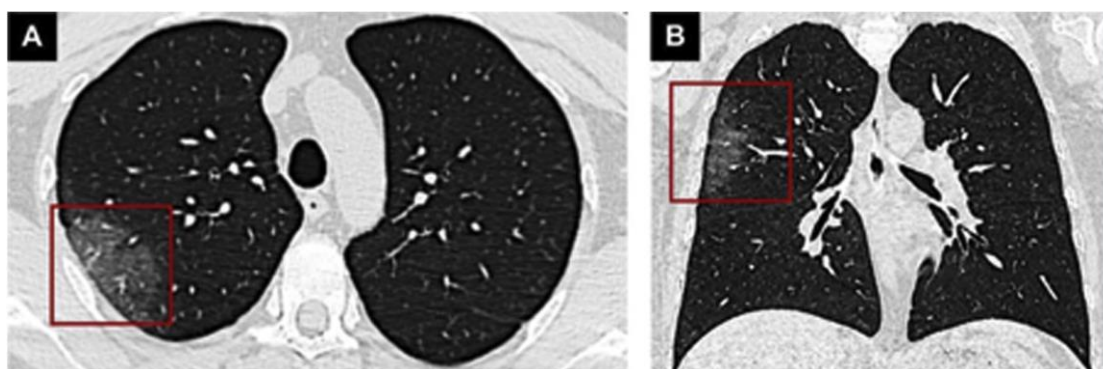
CT findings of early-stage COVID-19. A 36-year-old male with a history of close contact with confirmed cases. Fever had been present for six days. Chest CT shows a unilateral pure GGO (ground glass opacity) lesion (red rectangles) in the posterior segment of the right upper lobe on axial (A) and coronal view (B).
